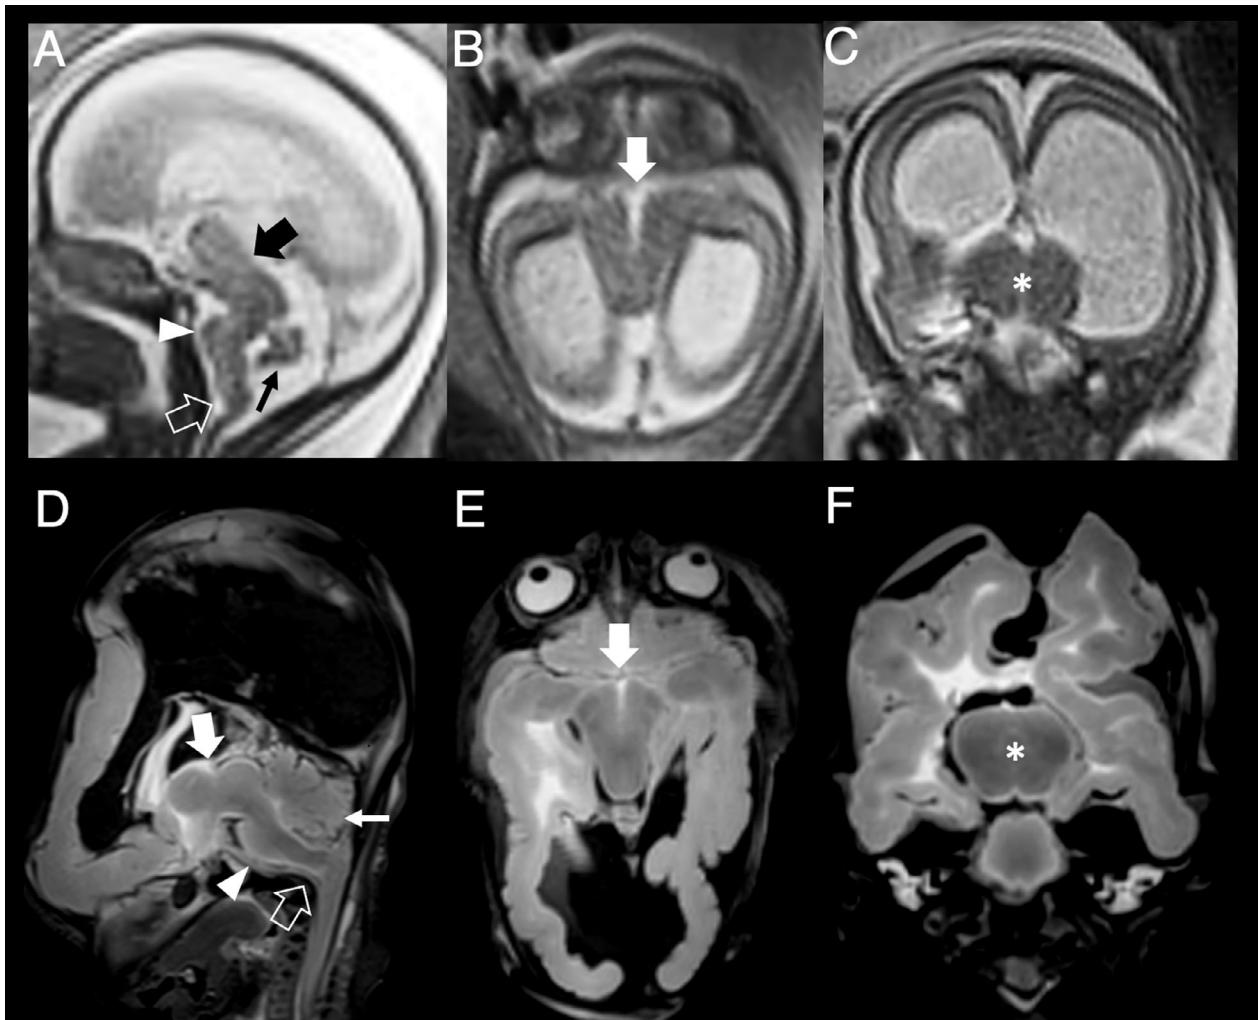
Fetal brain MRI (A–C) and post-mortem MRI (D–F) in a 22-week-old fetus. Sagittal (A, D), axial (B, E), and coronal (C, F) T2-weighted images show the most frequent neuroimaging pattern, characterized by obstructive hydrocephalus, marked thinning of the corpus callosum, diencephalosynapsis (asterisks), features of DMJD type B on the sagittal plane (thick arrows, A, D), features of DMJD type A with typical butterfly appearance of the midbrain on the axial plane (thick arrows, B, E), brainstem kinking (empty arrows), pontine hypoplasia (arrowheads), and small vermis (thin arrows).
